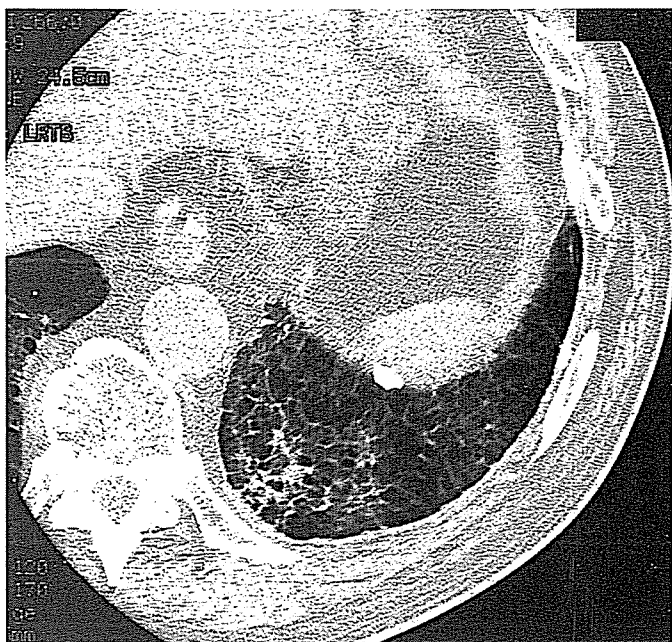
Visceral pleural thickening in asbestosis. HRCT shows reticular abnormality with traction bronchiectasis. Note the fine irregularity of the visceral pleura, which differs from the smooth interface seen with parietal pleural plaques.
